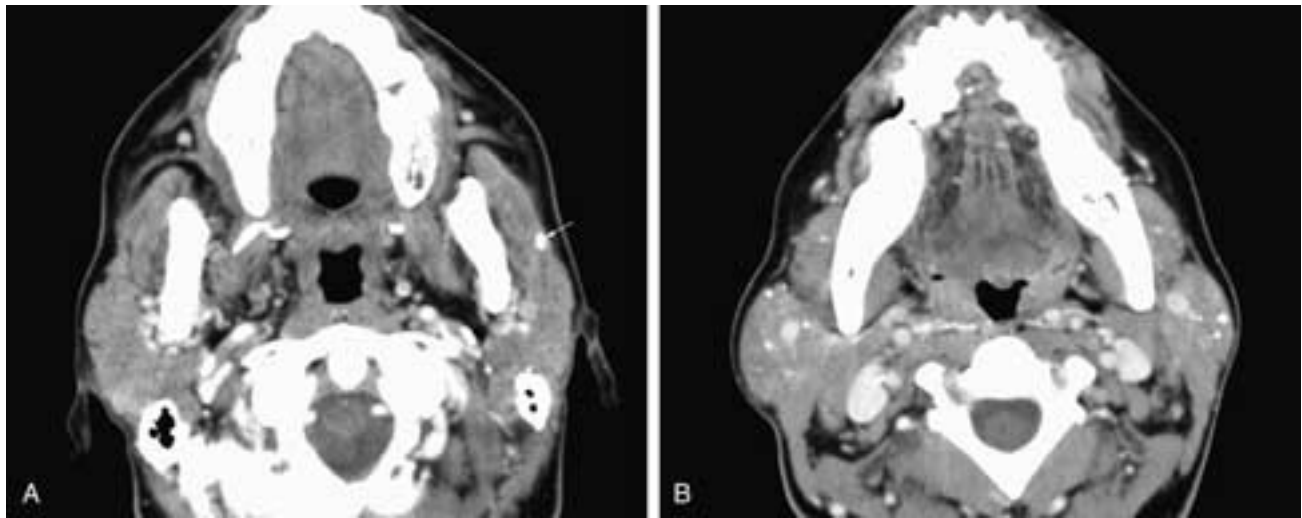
Axial contrast-enhanced CT scans (A, B) show multiple sialoliths in both parotid glands. Only the stone near the hilum of the left parotid gland (*arrow*) is causing symptoms of acute sialadenitis as it obstructs and dilates the main glandular duct immediately proximal to it.
